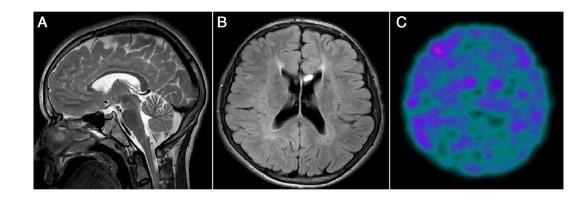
(A) Sagittal T₂-weighted brain MRI showing marked thinning of corpus callosum. (B) Axial FLAIR brain MRI showing hypersignal of the anterior periventricular white matter, "ears of the lynx sign". (C) [99mTc] TRODAT-1 SPECT showed markedly reduced dopamine transporter levels in the striatum.
